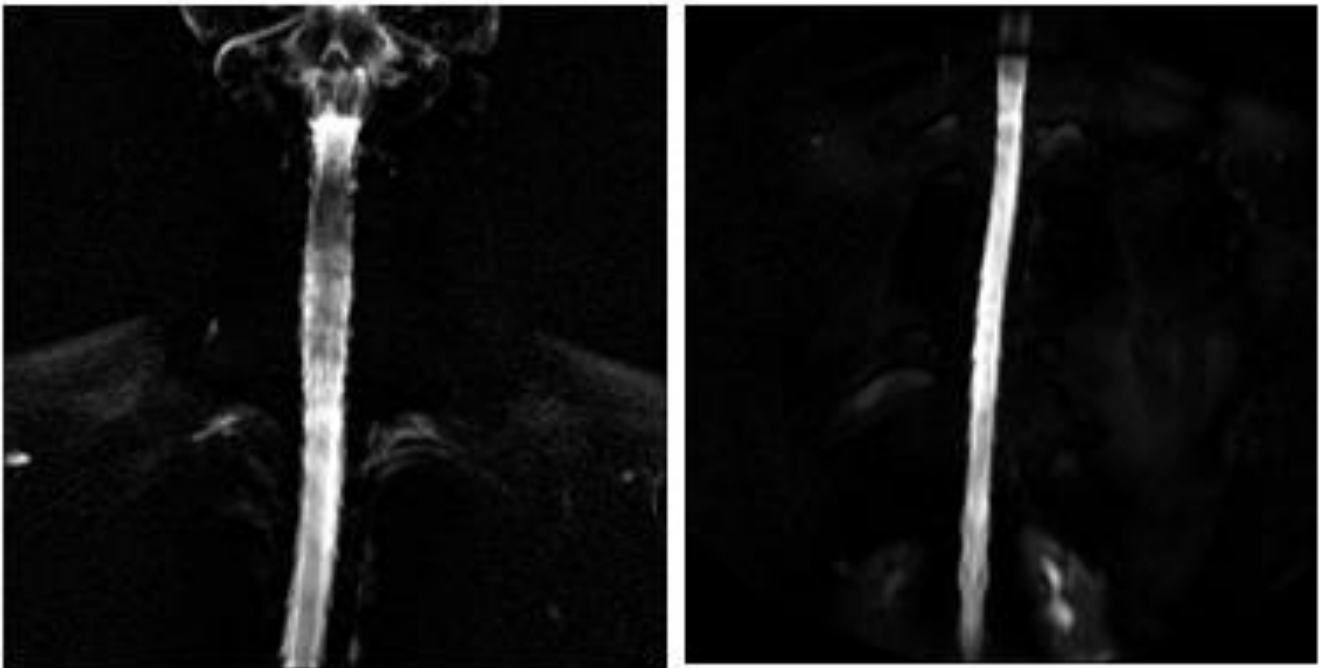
Contrast-enhanced spinal MRI did not show CSF leakage
